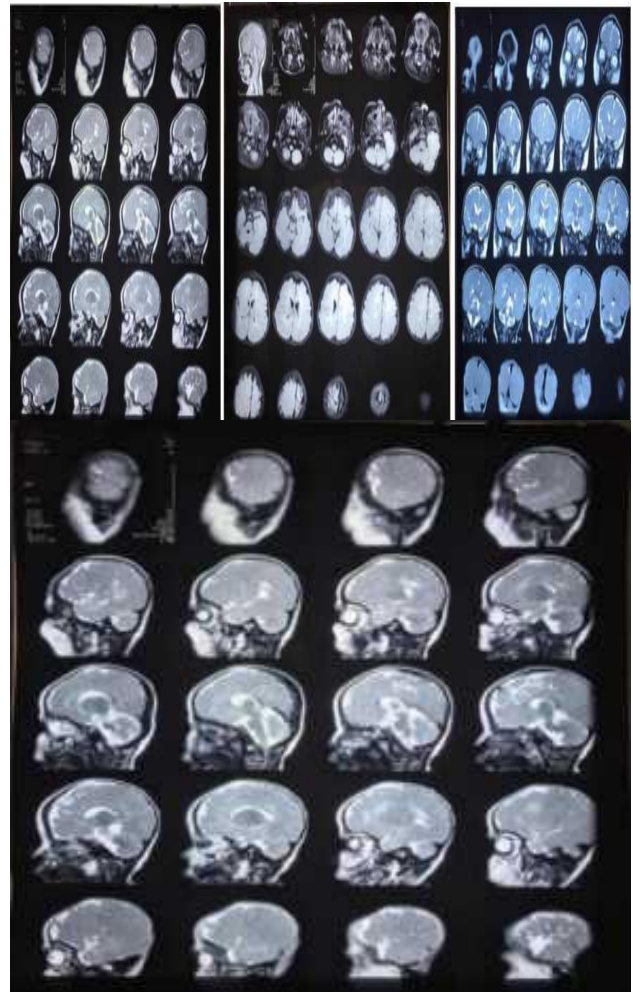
MRI brain showing incomplete periventricular deep white matter myelination; bilateral temporal and frontal atrophy.
